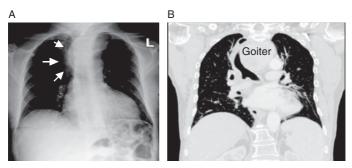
Chest radiograph (A) and coronal view chest computed tomography scan (B) showing a large substernal goiter (*arrows* in A) deviating the trachea to the right. L = left.
